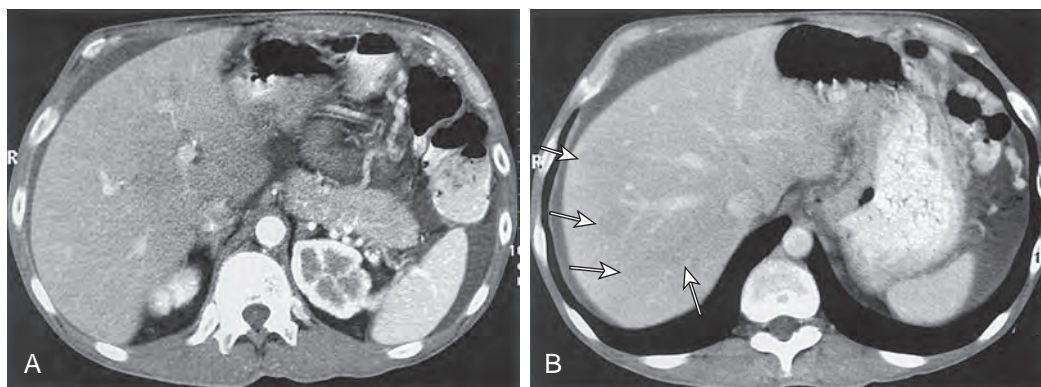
Importance of timing of contrast material bolus in liver lesion detection on CT. To evaluate a possible pancreatic mass, a thin-collimation spiral was obtained from the inferior pancreas upward, with a second spiral covering the cranial portion of the liver. Although present on subsequent ultrasound, no metastases were detected on the lower image (A) because scanning occurred during the arterial phase. The more cranial portal venous phase image (B) demonstrates multiple metastases (arrows) from a nonhypervascular carcinoid tumor.
